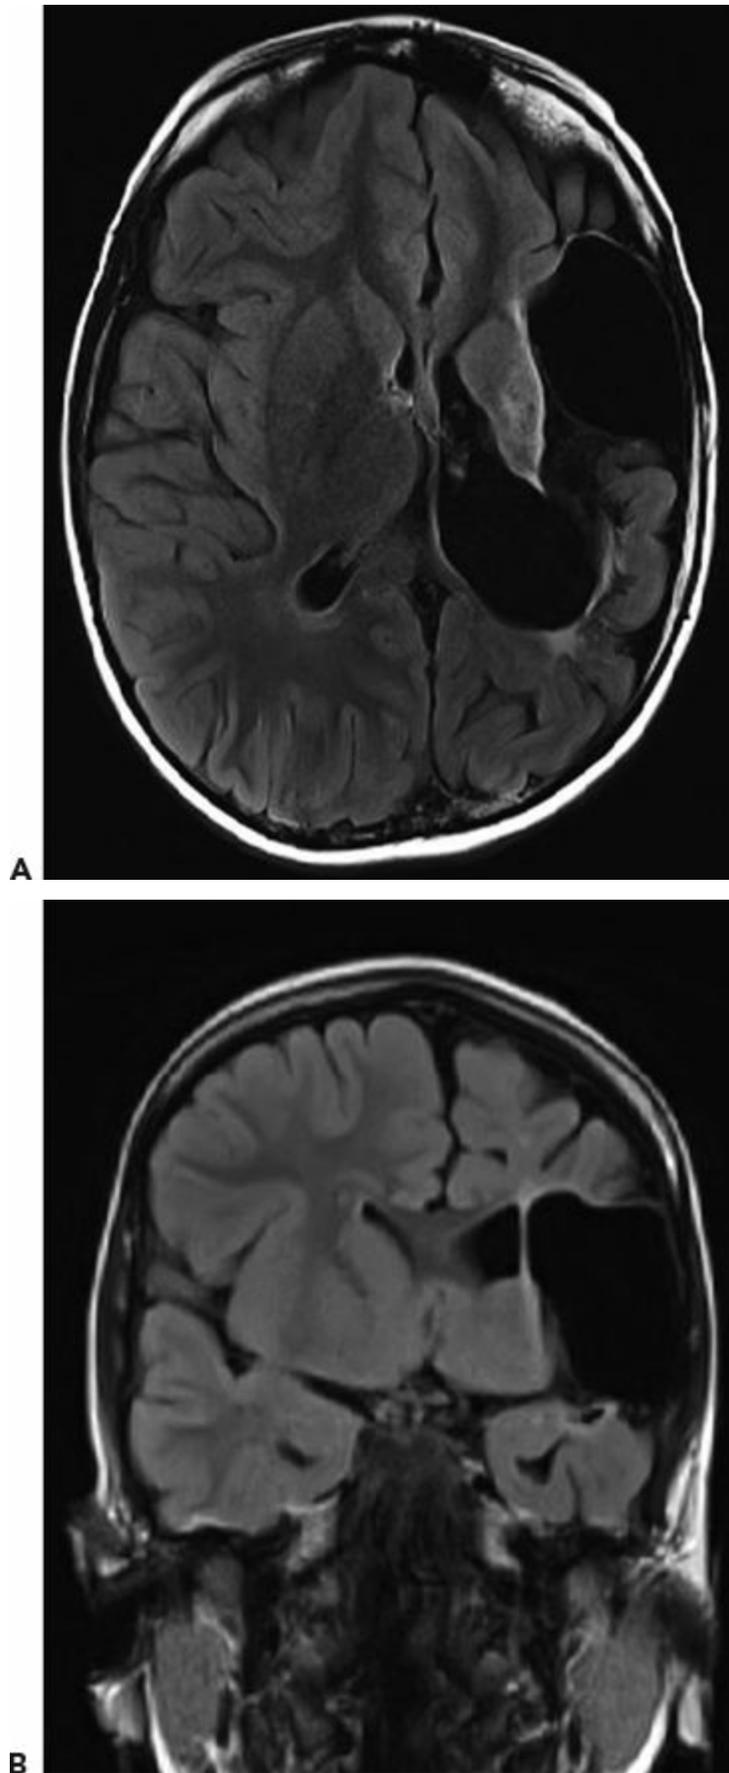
Early developmental lesion in a patient with CSWS. An extensive cystic encephalomalacia affects the left hemisphere in the distribution of the left middle cerebral artery. The patient suffered a perinatal stroke. A: Axial view, T2-weighted FLAIR MRI. B: Coronal view, T2-weighted FLAIR MRI.
